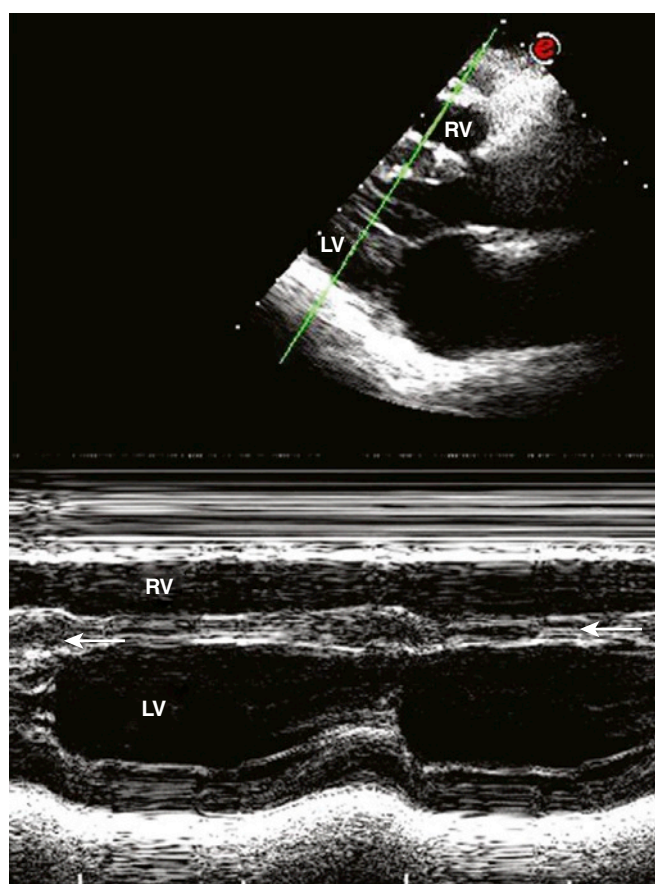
Echocardiography depicts dyskinesia of the interventricular septum (*arrow*) in a patient with Takayasu's arteritis. LV, left ventricle; RV, right ventricle.
